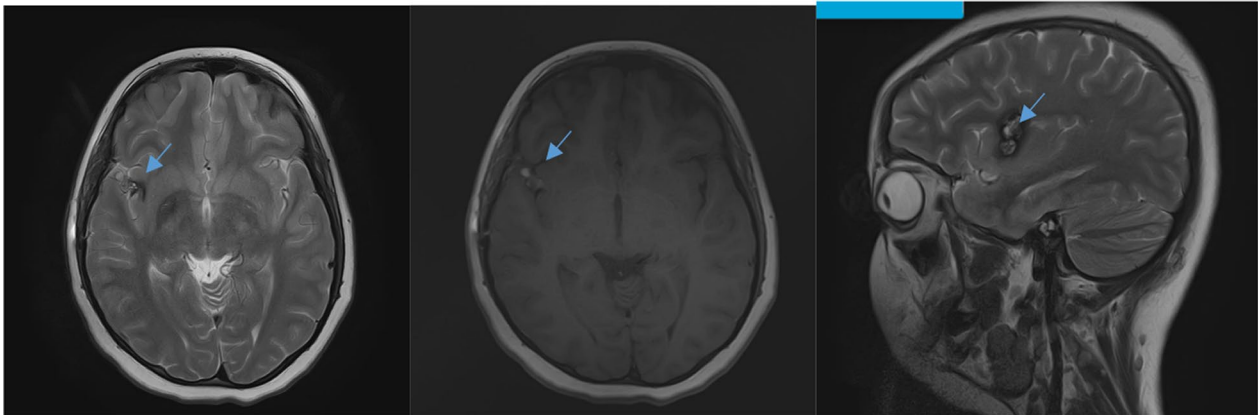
Postoperative MRI: Status post-craniotomy with interval development of resection cavity in the right insular region. *Arrow showing redemonstration of lobulated abnormal signal intensity area medial to the surgical cavity representing residual cavernoma
